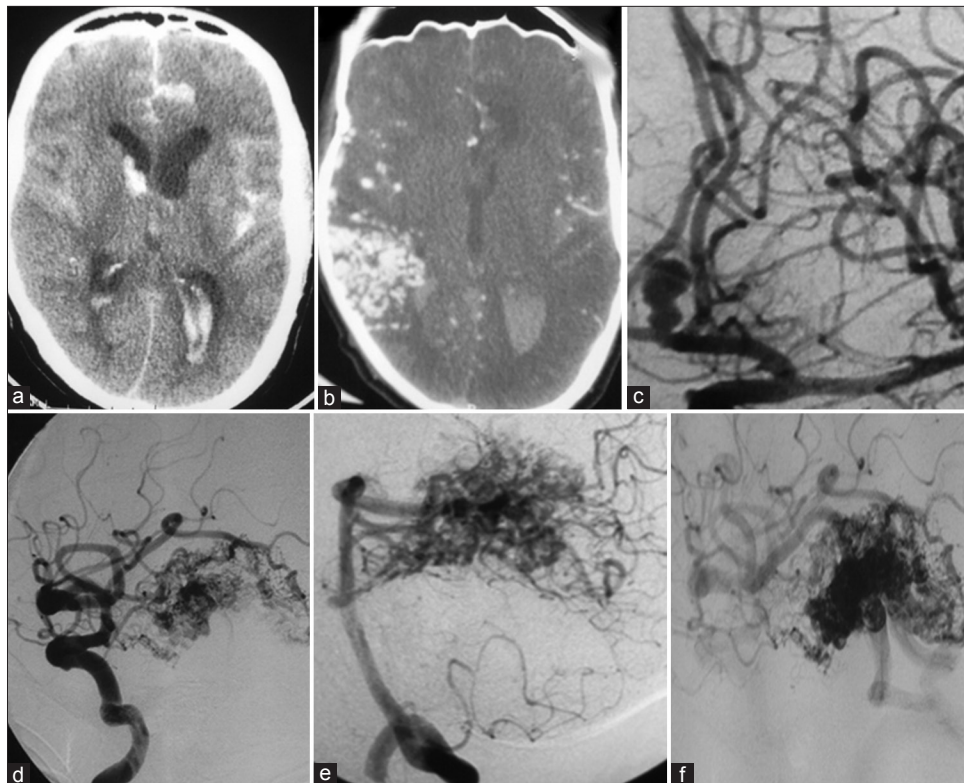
Patient 6 - (a) Axial contrast enhanced computed tomography scan showing blood in the interhemispheric fissure, bilateral sylvian cisterns and lateral ventricles, (b) Serpiginous contrast enhancing hyperdensity indicative of arteriovenous malformation (AVM) in the right posterior temporal region, (c) AP view of internal carotid artery (ICA) digital subtraction angiogram (DSA) showing anterior communicating artery aneurysm, (d) Lateral view of ICA DSA showing the posterior temporal AVM supplied by right middle cerebral artery, (e) Lateral view of right vertebral DSA showing AVM supply also from right posterior cerebral artery, (f) Venous drainage into the right transverse sinus
